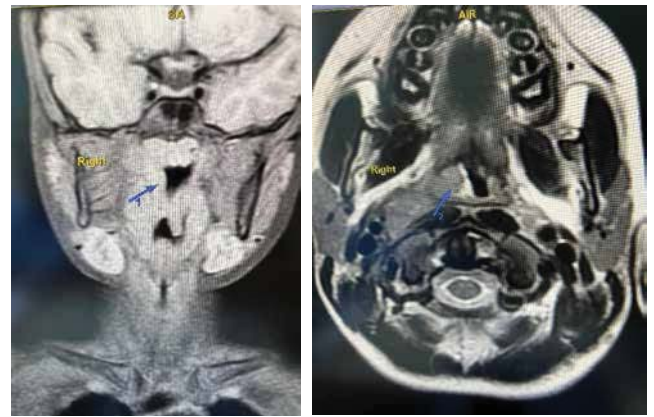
MRI findings: right-sided tonsillitis and cervical lymphadenopathy. The right palatine tonsil is enlarged with well-defined but irregular contours; its structure appears homogeneous. A peripheral hyperintense MRI signal due to edema is observed (indicated by arrows)
